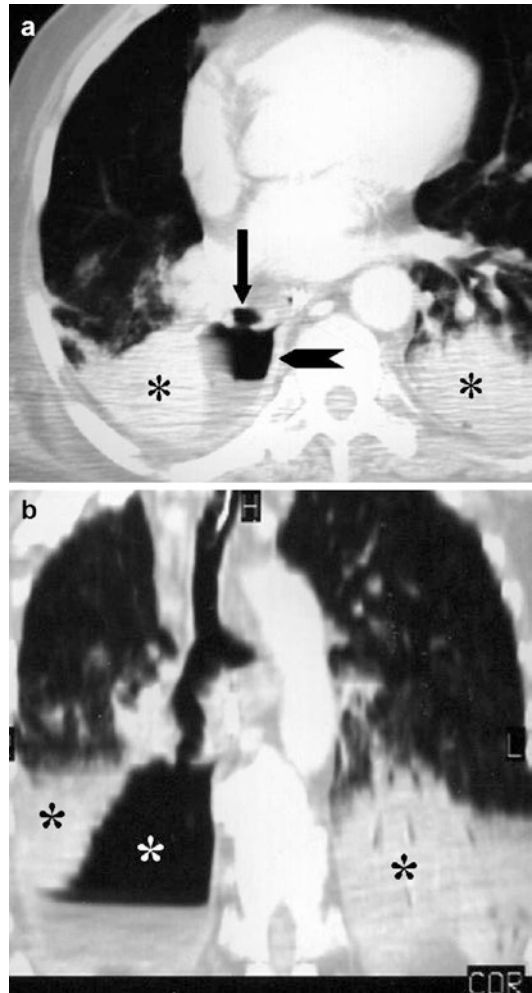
Penetrating trauma after bronchoscopy. (a) CT scan shows right middle bronchus defect (*arrow*) in direct communication with an air-leveled area indicating hydropneumothorax (*arrowhead*). In addition, bilateral pulmonary atelectasis (*asterisks*) is also visible. (b) Frontal MPR reformation shows the right middle bronchial discontinuity and the longitudinal extension of the hydropneumothorax (*white asterisk*). Pulmonary atelectasis (*black asterisk*) (Reproduced with permission from Elsevier)
